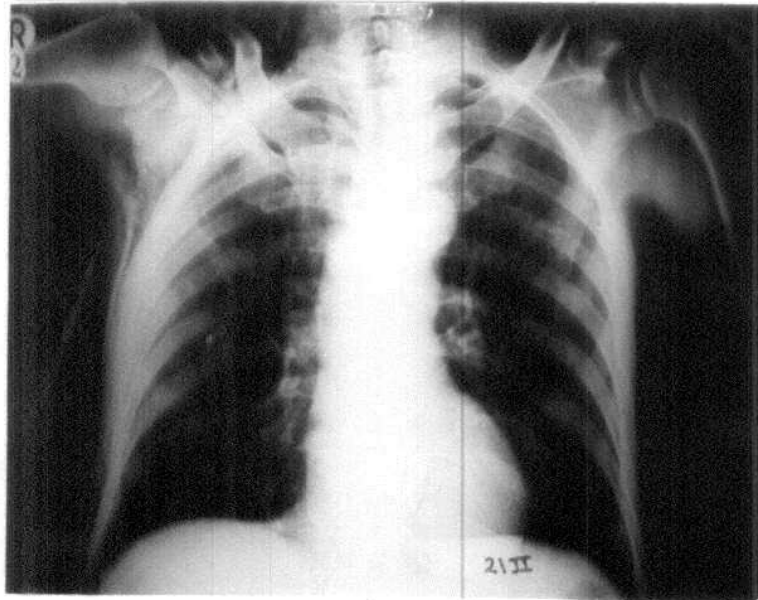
Postoperative chest radiograph for patient No. 21 II (24 hours after surgery): showing right sided surgical emphysema.
